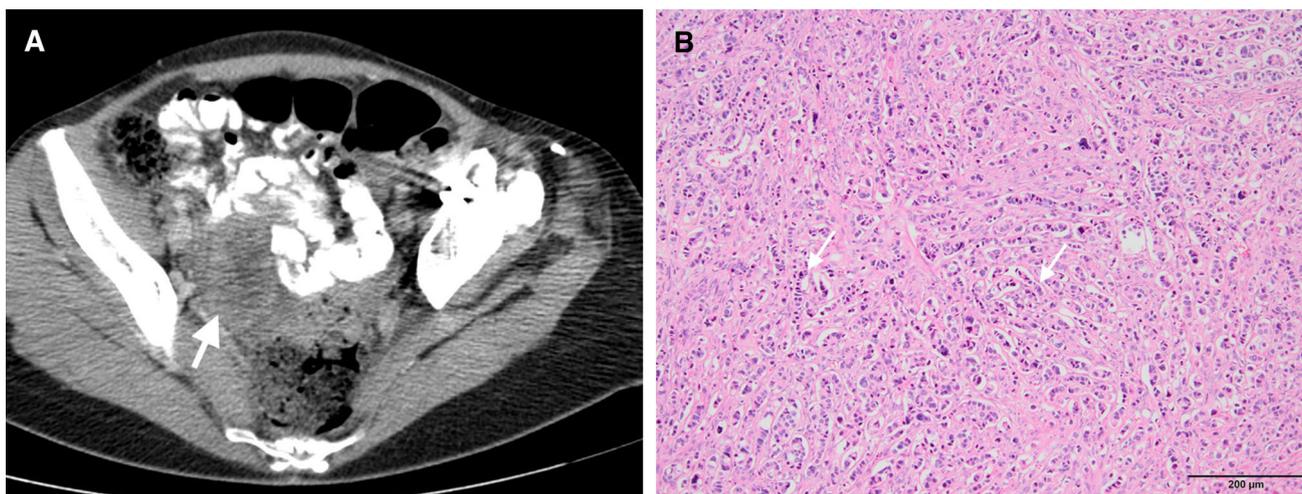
Fifty-five-year-old woman with a history of surgically and medically treated breast cancer. She was under clinical and radiological remission for 3 years after the end of her therapy. A recent CT scan was performed for surveillance. A Axial post-contrast CT image demonstrated asymmetrically
